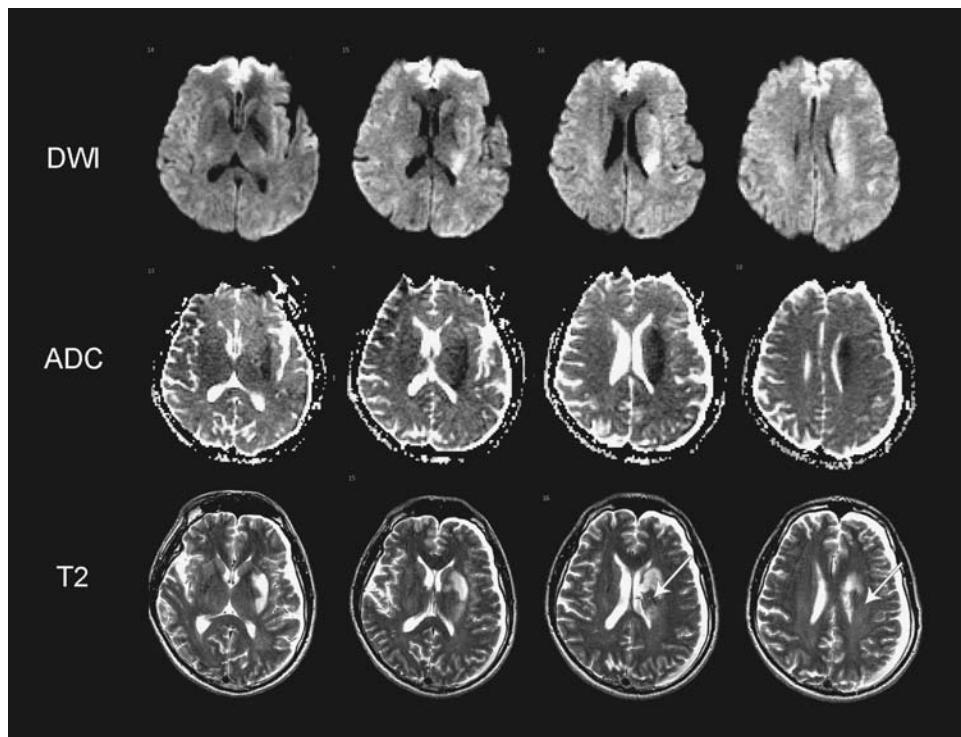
Acute ischemic stroke with DWI reversibility. Sixty-five-year-old male with sudden onset of right-sided weakness and slurred speech. CTA (not shown) demonstrated left M1 occlusion. He was treated with IA rtPA with near complete recanalization. DWI images and ADC maps demonstrate acute ischemia involving the left external capsule, caudate body, corona radiata, and parietal subcortical white matter. Follow-up T2-weighted images demonstrate hyperintensity, consistent with infarction in the putamen, external capsule and part of the caudate body, and corona radiata. However, part of the corona radiata and caudate body appear normal on the follow-up T2-weighted images (arrows). In addition, the left parietal lesion is not seen. Abbreviations: DWI, diffusion-weighted images; ADC, apparent diffusion coefficient; rtPA, recombinant tissue plasminogen activator; CTA, computer tomography angiography.
